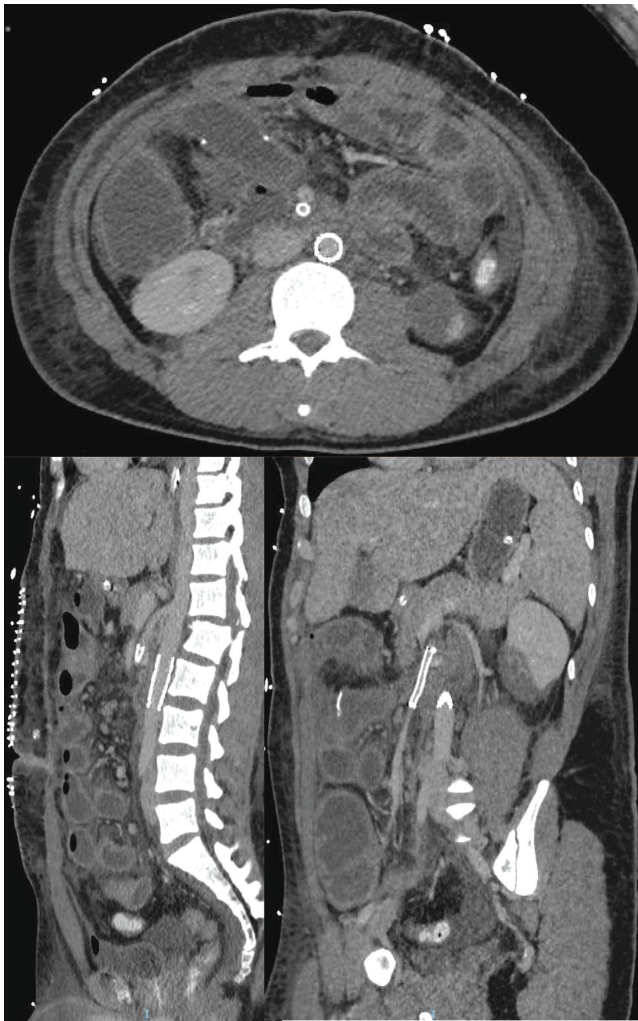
Control CT angiography with aortic Bgraft and Viabahn patency in SMA.
